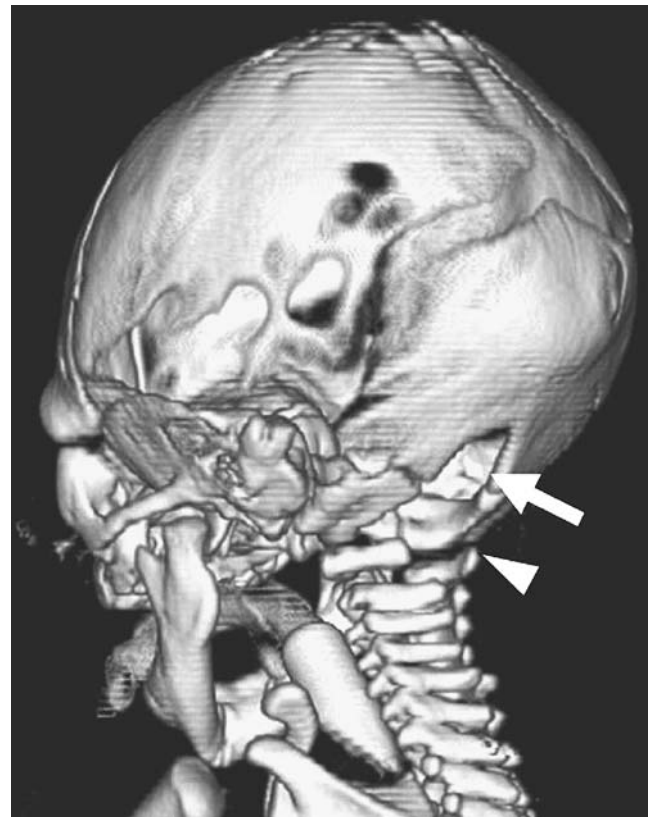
The 3-D reformation from an axial CT scan demonstrates the defect in the occipital bone (*arrow*) and posterior aspect of the C1 vertebral body (*arrowhead*)
